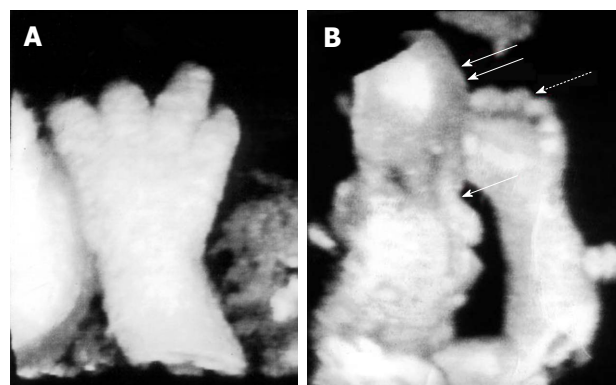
Skeletal anomalies detected by three-dimensional ultrasonography. A: Trident configuration of the digits and brachydactyly suggestive of achondroplasia; B: Facial dysmorphisms: frontal bossing (double arrows) and flattened mid-face (single arrow), disproportionate limb segments and brachydactyly (dotted arrow) typical of achondroplasia. Adapted from Krakow *et al.*^[108].
